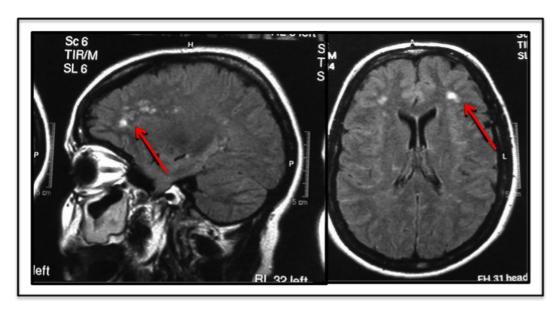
Image obtained through application of MRI of a relapsing remitting MS patient. Red arrows indicate lesions in the white matter of the brain caused by demyelination. (Source: Prof SJ van Rensburg, with permission)
